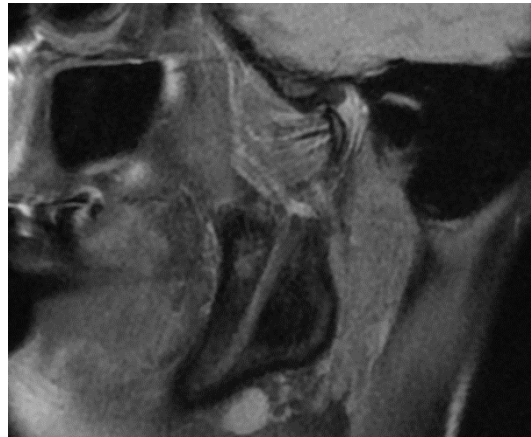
Open mouth PD MRI sagittal image of the left temporomandibular joint: the articular disc remains anteriorly displaced relative to the condyle: disc displacement without reduction.
